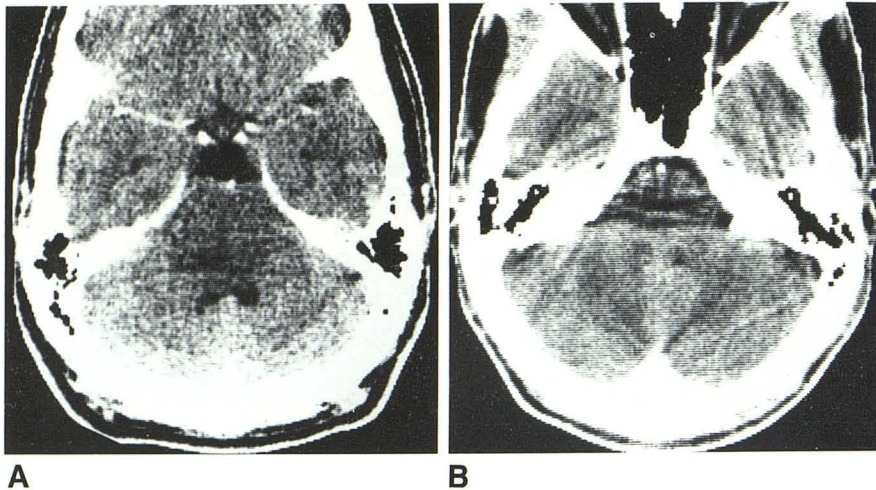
Contrast-enhanced CT scans. A, Slight compression of floor of fourth ventricle and basal cisterns. Brainstem has slightly decreased attenuation. B, Probable compression of fourth ventricle.
